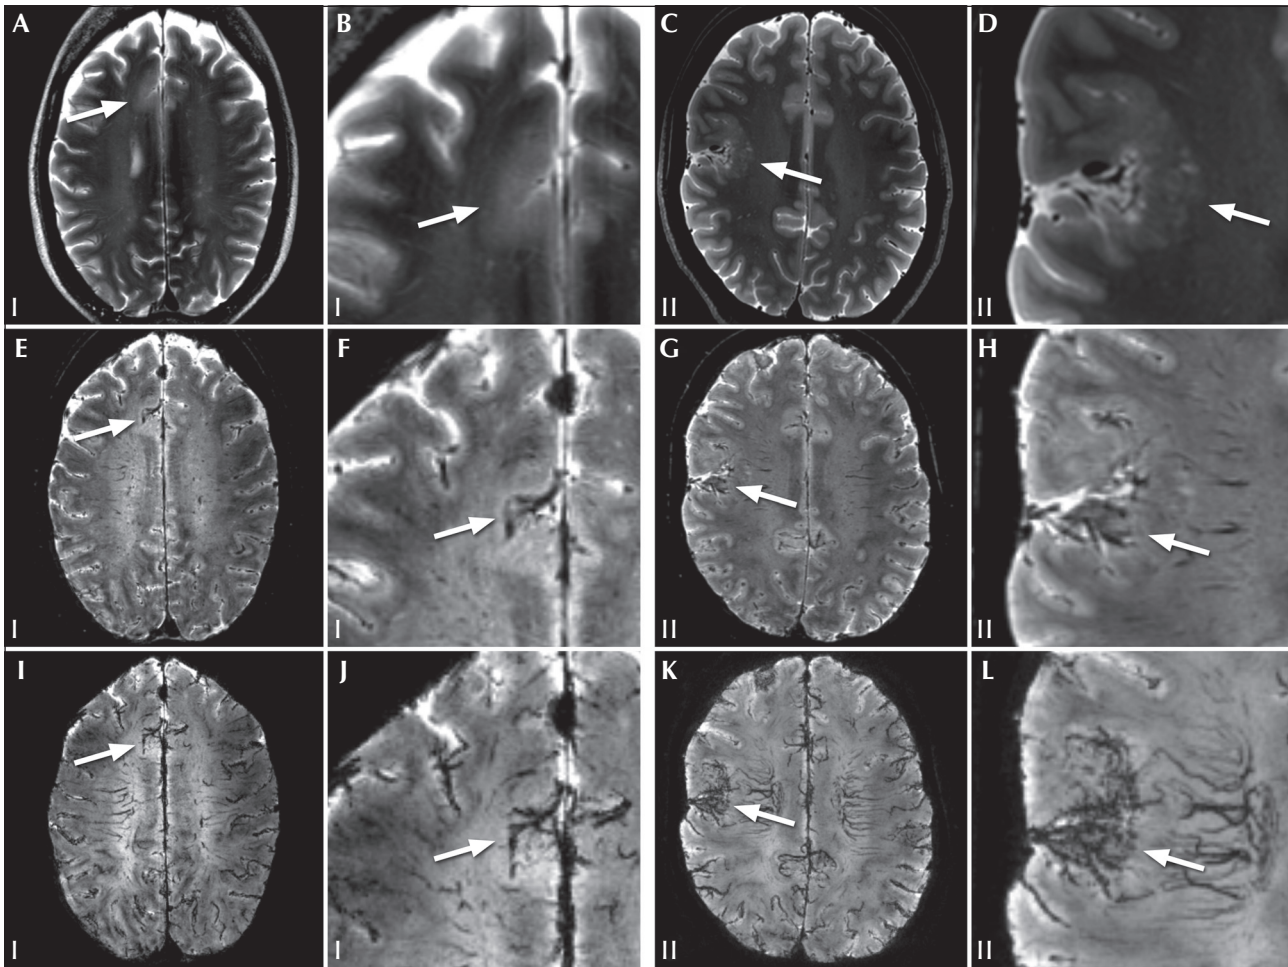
(A) MRI findings of patients with confirmed FCD and T_2^* signal changes; 7T T_2 (A-D), T_2^* (E-H) and T_2^* minimum intensity projection (I-L) transverse reconstructions. Lesions are depicted in detail in (B), (D), (F), (H), (J) and (L). Patient I; FCD ILAE type IIb (A, B, E, F, I, J). No lesion was identified on 3T MRI and subtle grey-white matter junction blurring was seen on 7T T_2 weighted MRI (A, B). On T_2^* (E, F), the neighbouring sulcus appears to contain prominent vasculature. T_2^* minimum intensity projection (I, J) aids in the visual detection. Patient II; FCD ILAE type Ib (C, D, G, H, K, L). T_2 -weighted MRI (C, D) shows grey-white matter junction blurring and cortical thickening indicative of FCD. In the same area, T_2^* (G, H) shows a wide sulcus with prominent vascular structures. T_2^* minimum intensity projection (K, L) strongly emphasizes the increased vasculature.
